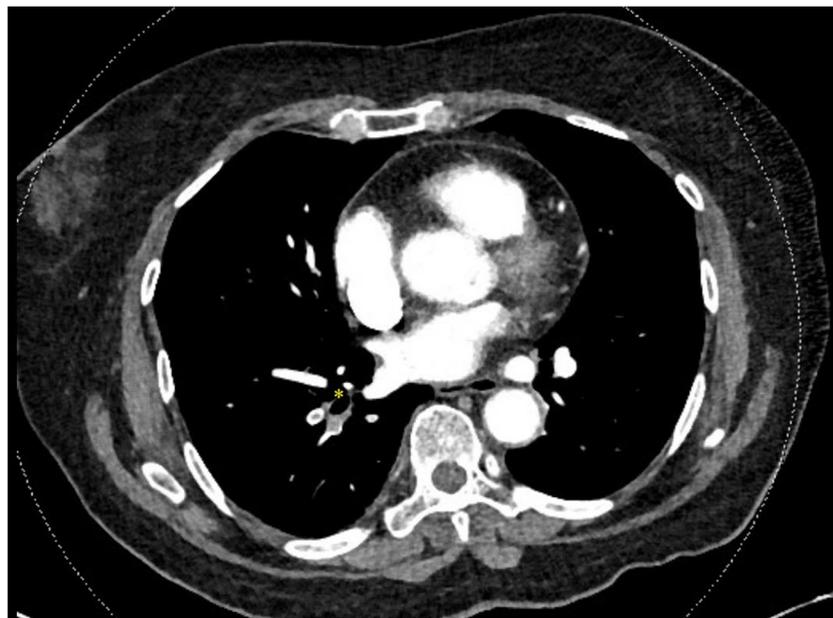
CT Pulmonary angiography showing filling defects most proximally within the lobar arteries (asterisk).
